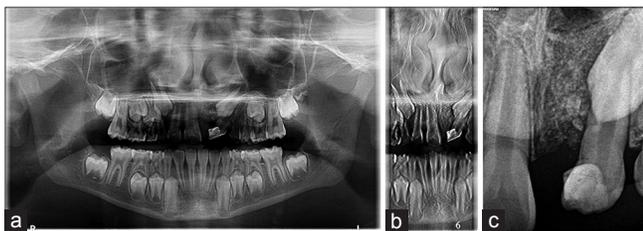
Five-month postoperative radiographs: (a) Orthopantomogram, (b) two-dimensional orthopantomogram, and (c) periapical X-ray
